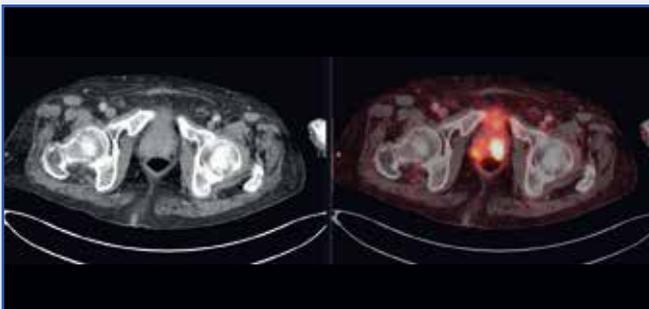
Ga-68 PSMA PET-CT distinctly displays a PSMA expressing nodule within the prostatic parenchyma confirming a second primary within the prostate which later on was deemed to be an adenocarcinoma.
